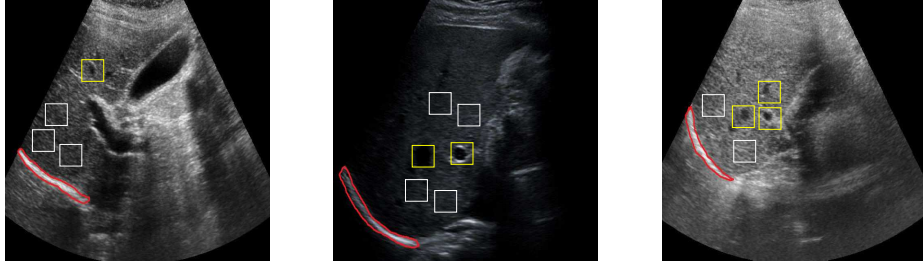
Ultrasonic liver images. Diaphragm region is enclosed with red contour, regions enclosed with yellow boxes indicates periportal veins and regions enclosed in white boxes represents homogeneous texture.
